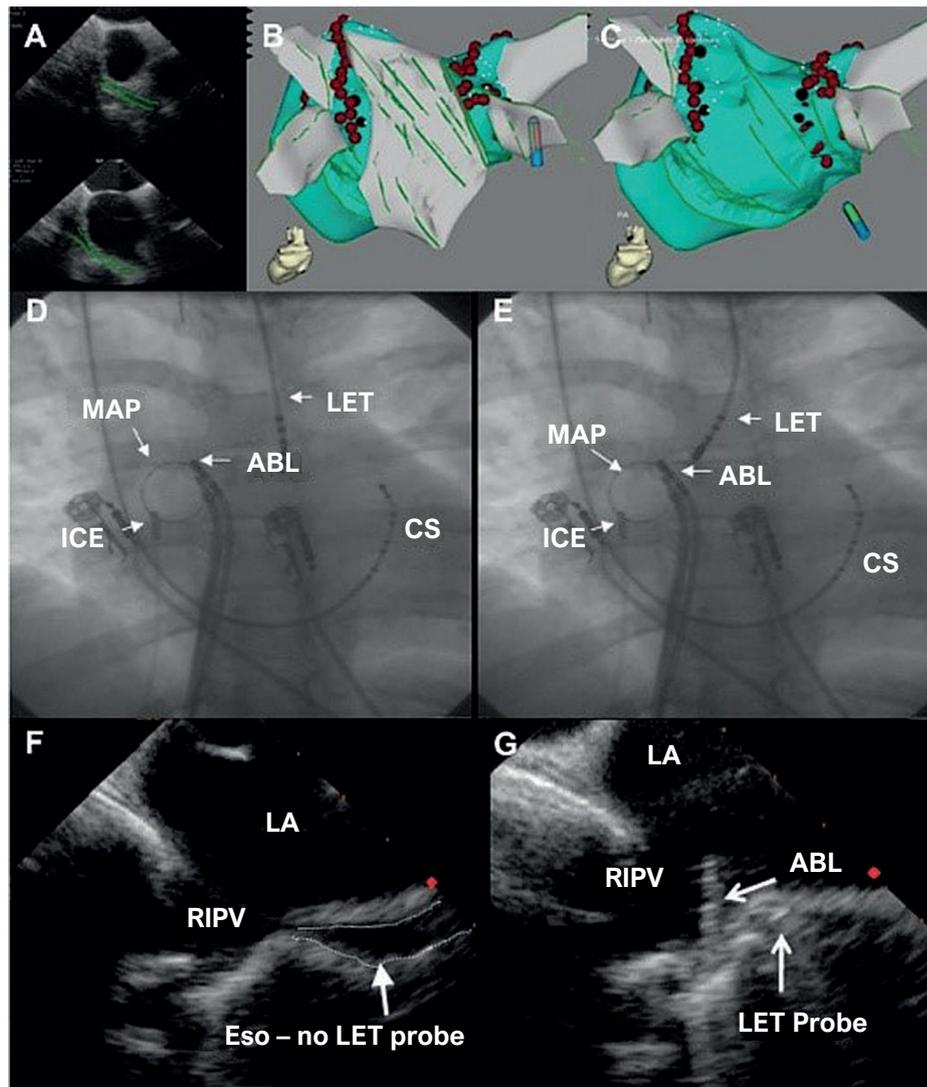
ICE-guided deflection of the esophageal temperature monitoring catheter. A: ICE showing the esophagus in relation to the left and right PVs (green contours); B: Esophagus (in gray) visualized in the electroanatomic map, broad and in contact with both left and right PVs; C: Electroanatomic map with black markers indicating esophageal temperature rise $>2^{\circ}\text{C}$; D: Fluoroscopy showing the luminal esophageal temperature (LET) probe in a neutral position, apparently distant from the right PVs; E: Fluoroscopy showing LET deflected to the right, approaching the ablation catheter; F: ICE image of the right PVs and esophagus without LET positioning, corresponding to fluoroscopic image D; G: ICE image with LET probe in place and in close proximity to the ablation catheter, corresponding to fluoroscopic image E. Eso: esophagus; MAP: circular mapping catheter; CS: coronary sinus catheter; LET: luminal esophageal temperature; ICE: Intracardiac echocardiography; LA: left atrium; RIPV: right inferior pulmonary vein; ABL: ablation catheter. Figure reproduced with permission from Leite L.R. et al.²⁸
